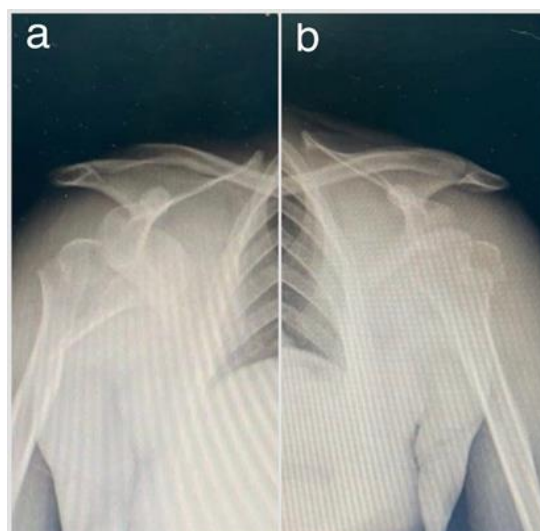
X-ray radiographs of the (a) right shoulder and (b) left shoulder.
